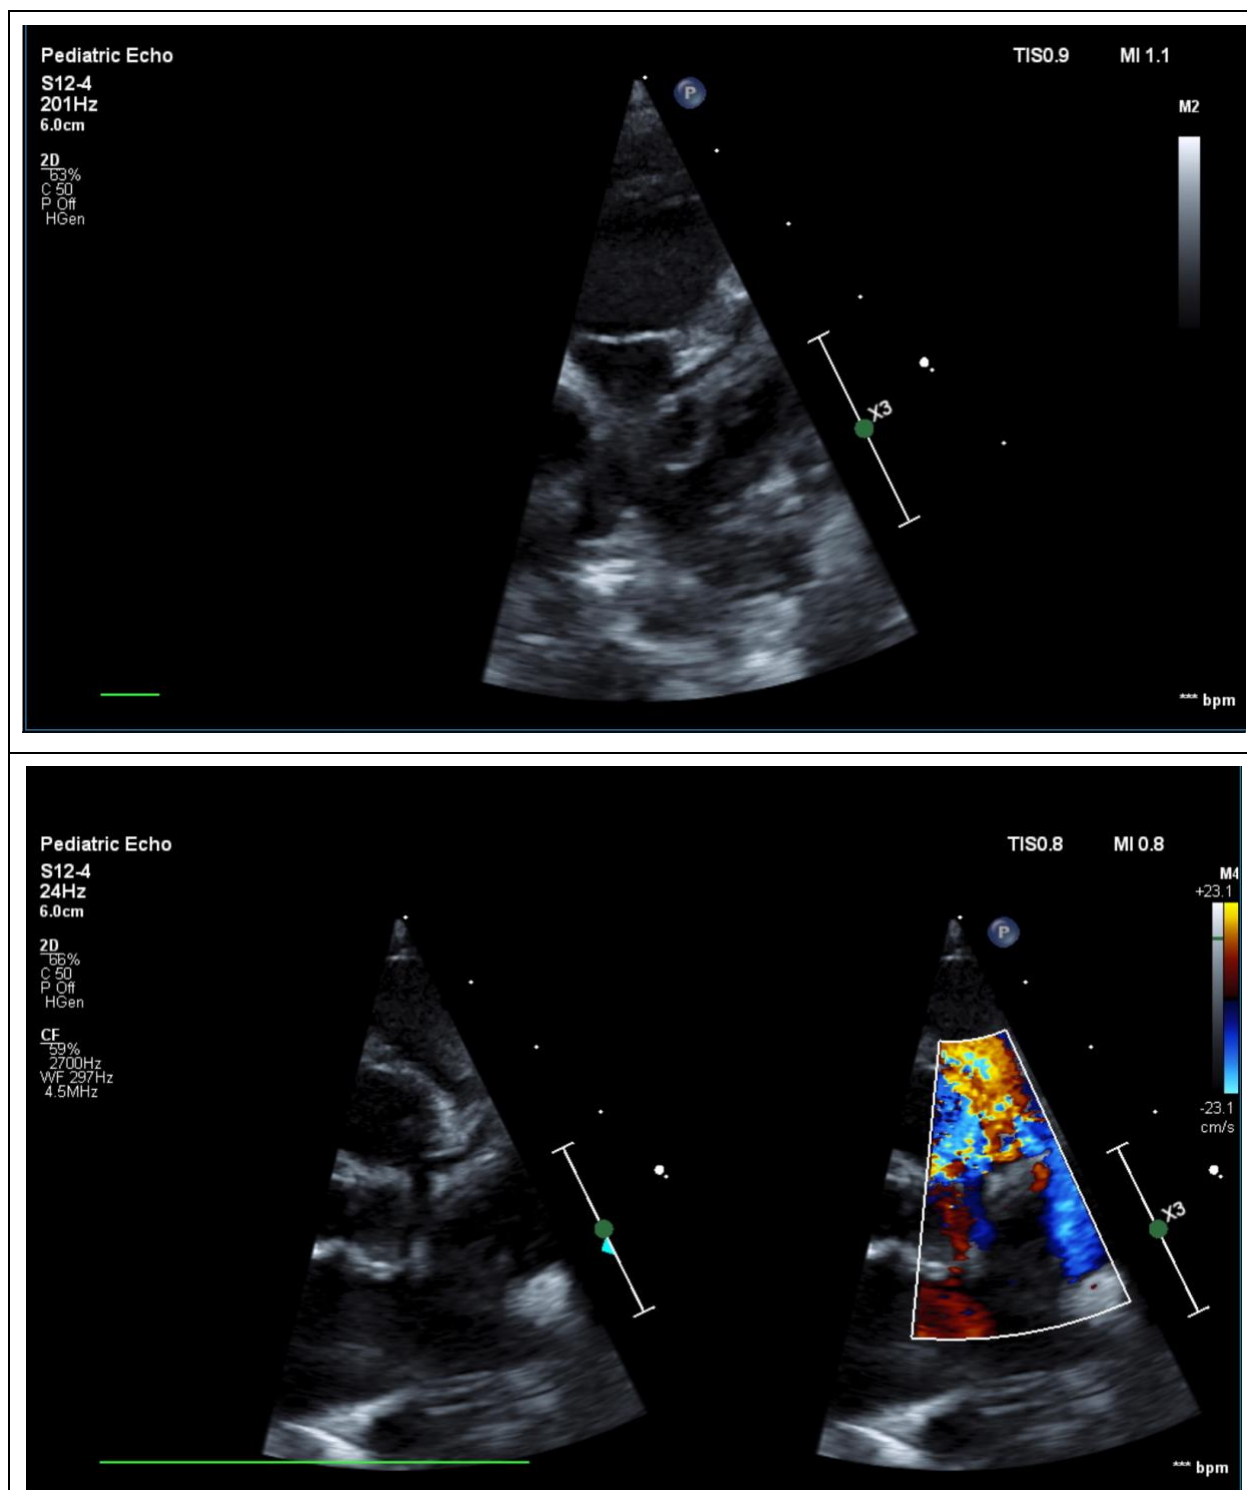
Transthoracic echocardiography with color Doppler showing anomalous origin of the left main coronary artery from the main pulmonary artery, retrograde flow in the left anterior descending coronary artery, severe left ventricular dilation, and reduced systolic function.
